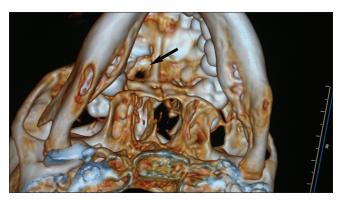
Plain axial computed tomography scan of midface with 3D reconstruction showing erosion and scalloping of the posterior part of the hard palate on the right side
